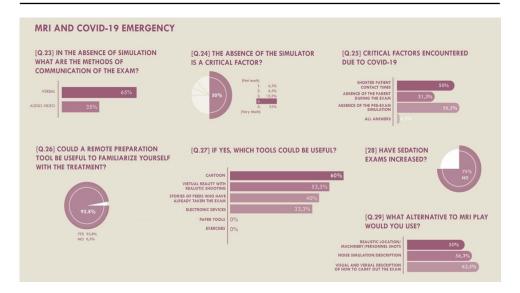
Results related to MRI procedures during the Covid-19 state of emergency.
